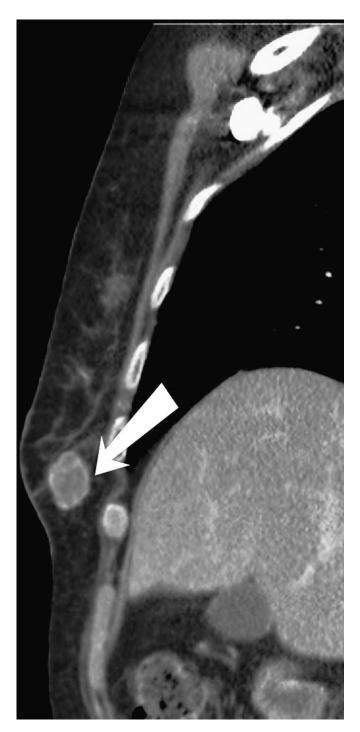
A 70-year-old woman with a known history of renal cell carcinoma, surgically resected 4 years earlier. Sagittal reconstruction of contrast-enhanced computed tomography reveals hypervascular breast deposit (white arrow), clinically palpable as a mass.
